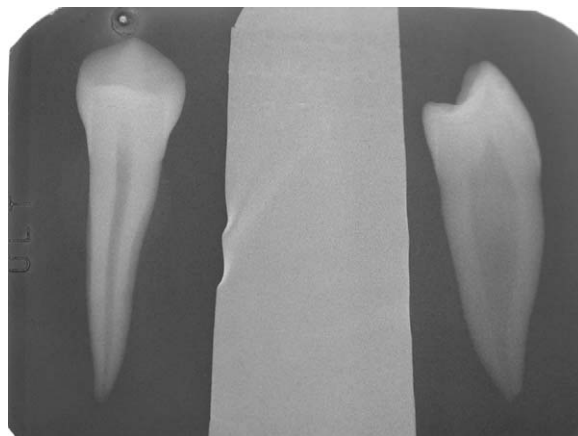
The faciolingual direction of the routine radiograph gives an impression of round-shaped canal in a mandibular first premolar. The mesiodistally directed radiograph indicates a flattened root canal in the same tooth.
